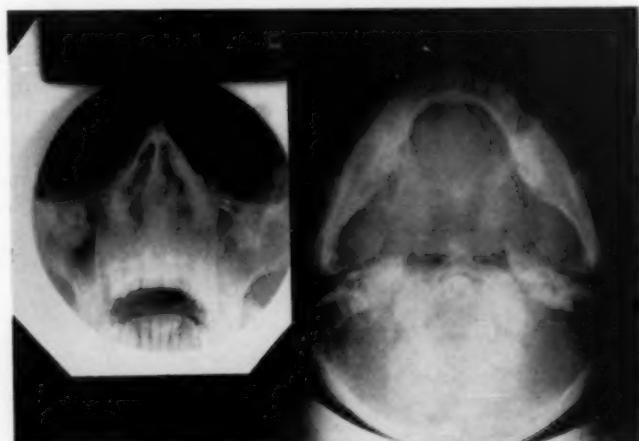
(Case 2).—Roentgenogram showing opacity involving left half of the nasal cavity and the base of the septum causing deviation and obstruction.
